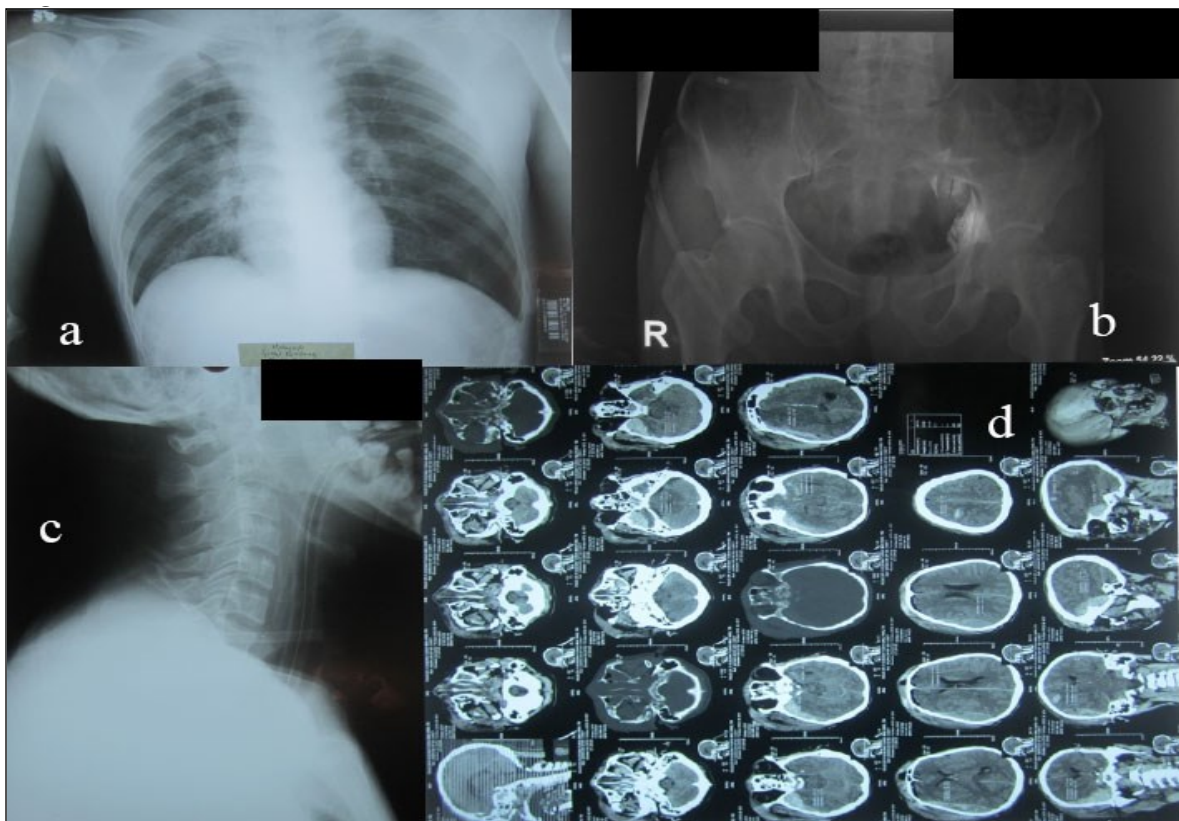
a. Plain Rontgen of Thoraks AP; Cor impression was within normal limits. Pulmo suggests a right lung infiltrate; b. Plain Rontgen of Pelvis presented within normal limits; c. Cervical Lateral Imaging was within normal limits; d. Head CT Scan without contrast: dextral temporo-basal EDH, dextral parietal contusional ICH, IVH, Le Fort II maxillary fracture. EDH = Epidural Hematoma; ICH = Intra Cerebral Hemorrhage; IVH = Intraventricular Hemorrhage.
